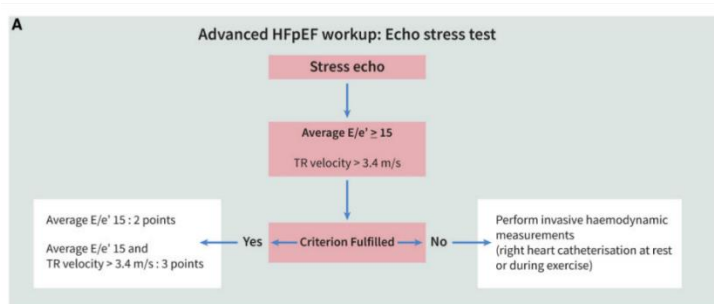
HFA-PEFF score, step 3 (F): Functional tests. It shows the diastolic stress test workup with exercise echocardiography is shown [22].
